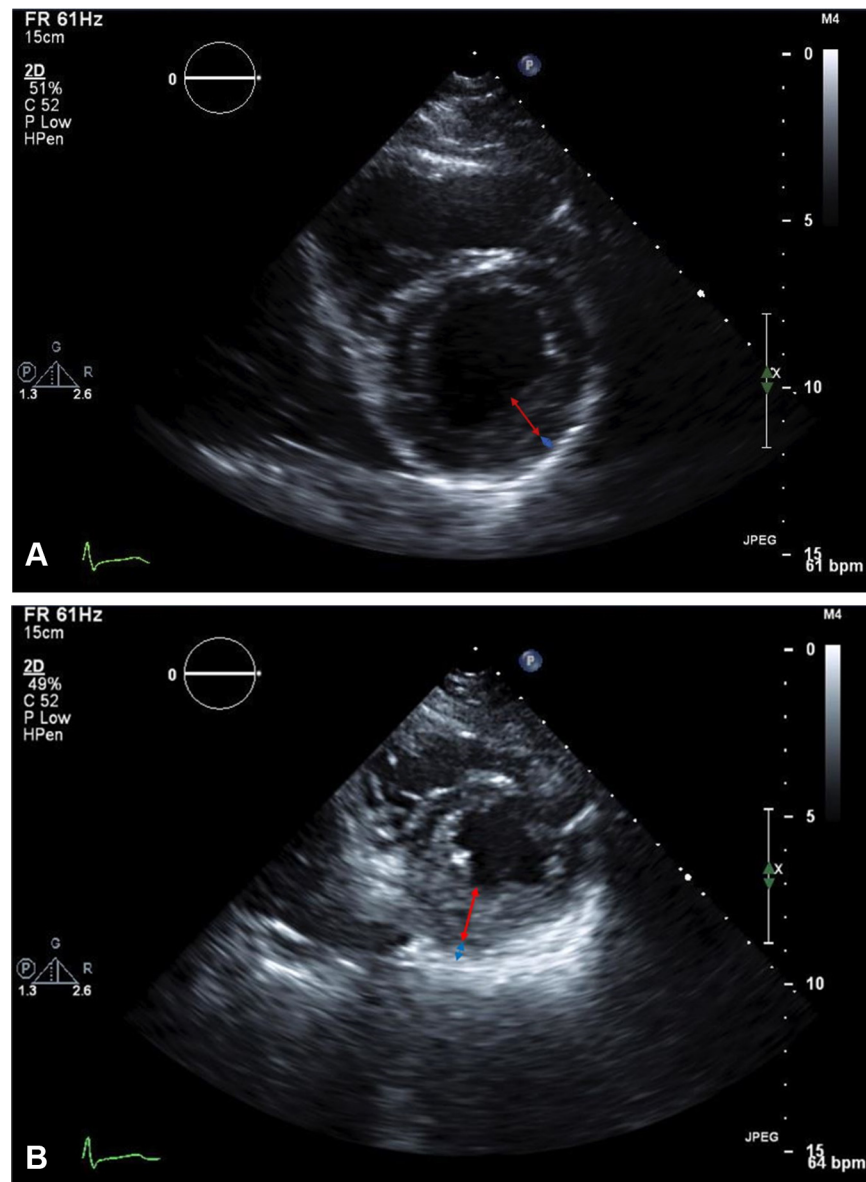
Transthoracic Echocardiogram at 22 Weeks' Gestation
